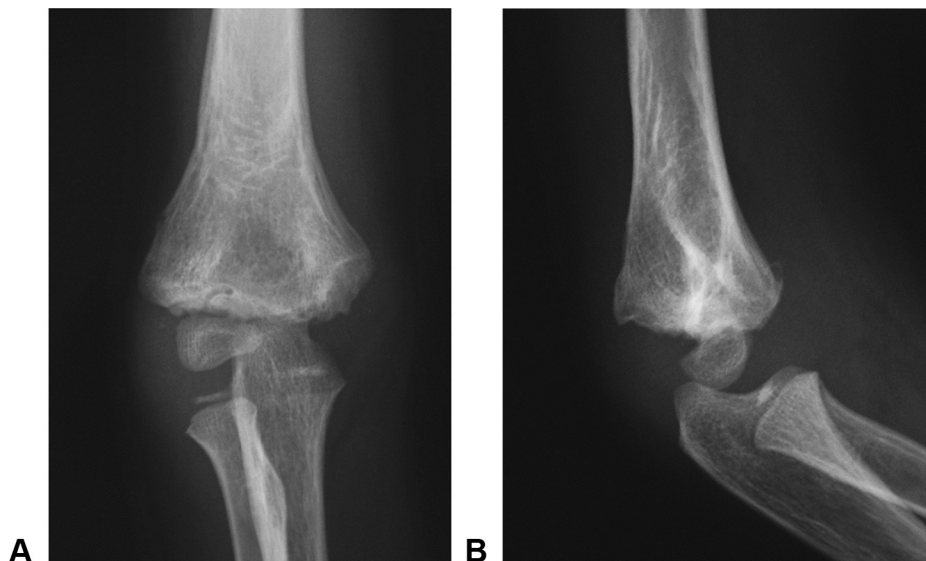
A Initial anteroposterior and B lateral radiographs of the right elbow showed a deformity of the distal humerus after a prior epiphyseal fracture-separation, but no new fracture lines.
